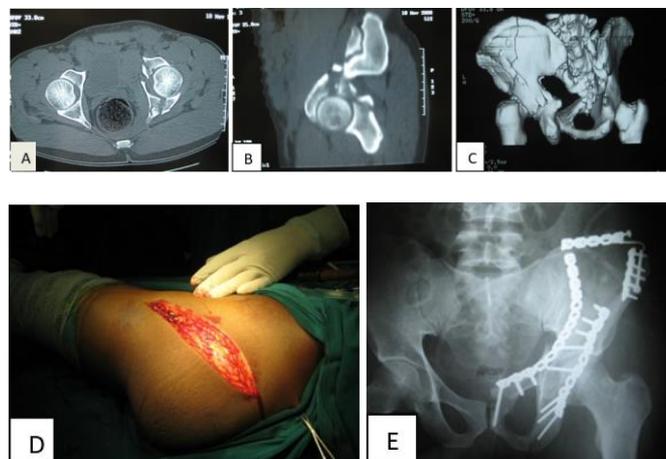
A, B: 36 yr. old male with fracture both column & associated fracture of posterior wall of acetabulum in CT pelvis. C: 3D reconstruction image of CT scan. D: It was treated with fixation of both columns through Kocher-Langenbeck and Ilioinguinal approach E: Post op x ray.
